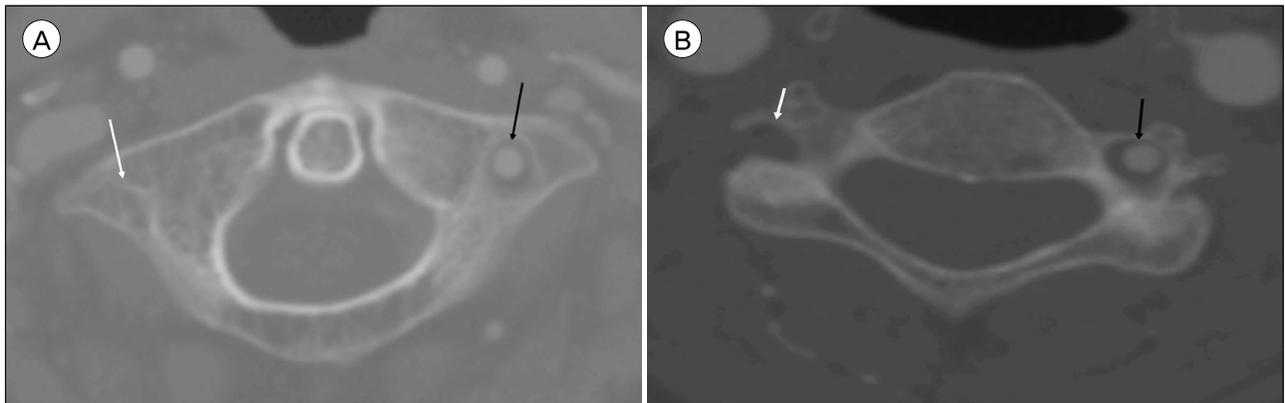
Axial computed tomography images at the level of the first (A) and fourth (B) vertebral bodies show absence of a right vertebral artery in the right transverse foramen (white arrow) but an intact left vertebral artery in the left transverse foramen (black arrow).
